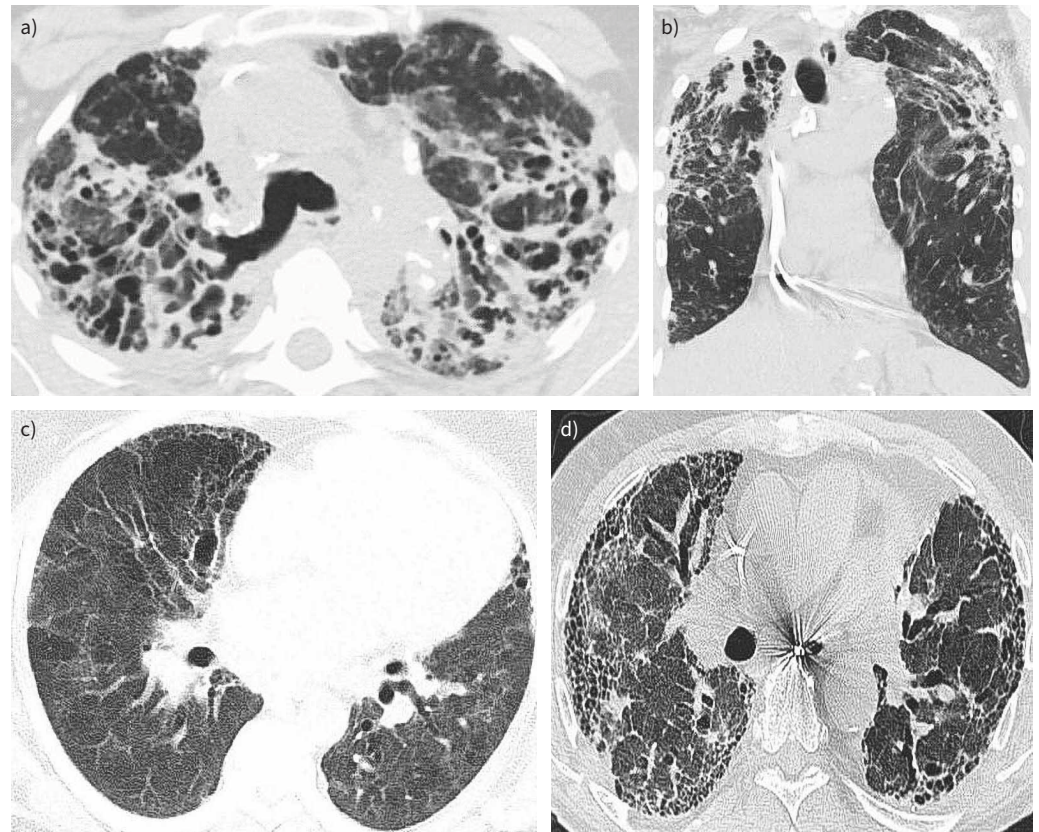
a) Sagittal plane of computed tomography (CT) demonstrating distribution of fibrosis in sarcoidosis. b) Typical coronal CT of sarcoidosis-associated pulmonary fibrosis (SAPF). c) Nonspecific interstitial pneumonia pattern of SAPF. d) Upper lobe usual interstitial pneumonia pattern of SAPF with mediastinal lymphadenopathy.
